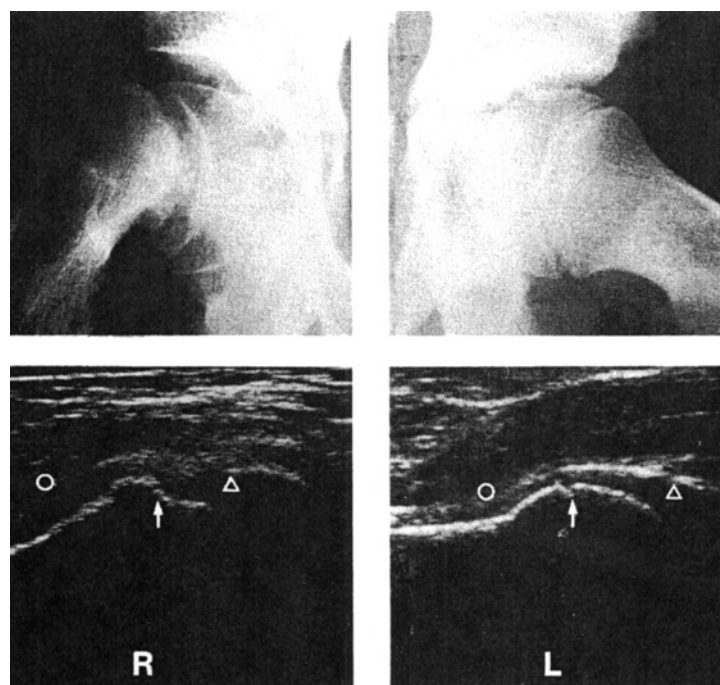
A. Anterior ultrasonograms and frog-leg lateral radiographs of a 12-year-old boy with a 10 mm physeal slip of his right hip (labels as in Figure 1). The anterior capsule distance of the right hip is increased, indicating a moderate hip effusion.
